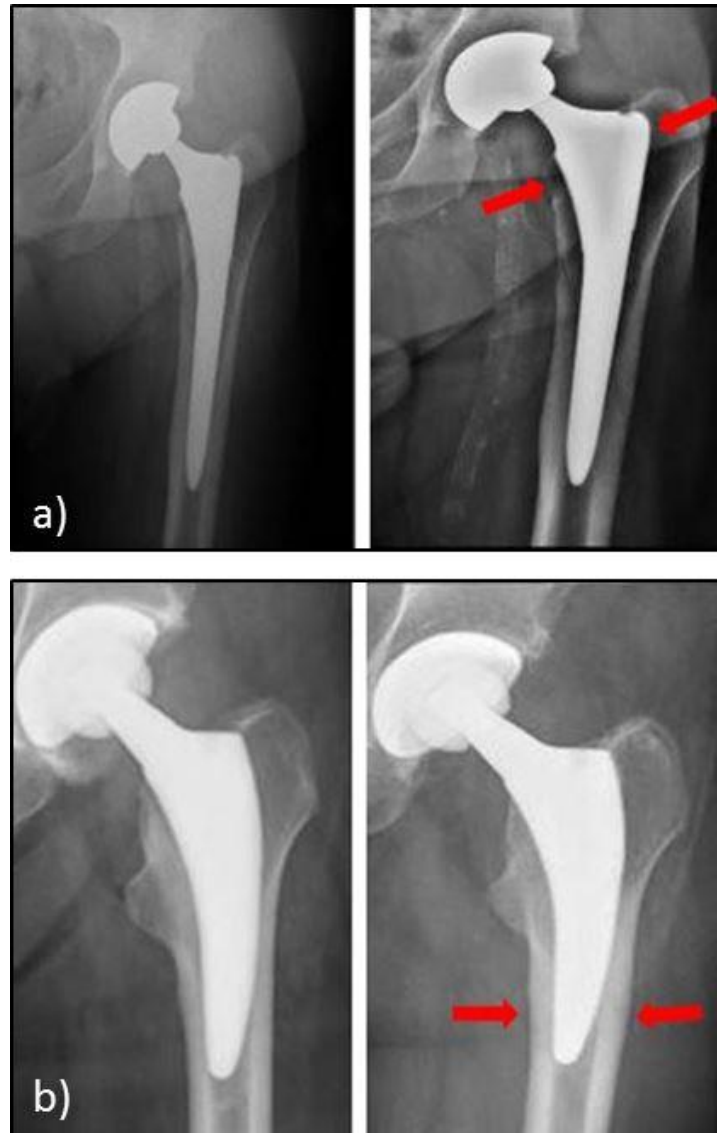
The X-ray images of THA with cementless stems show stress shielding and bone hypertrophy:
